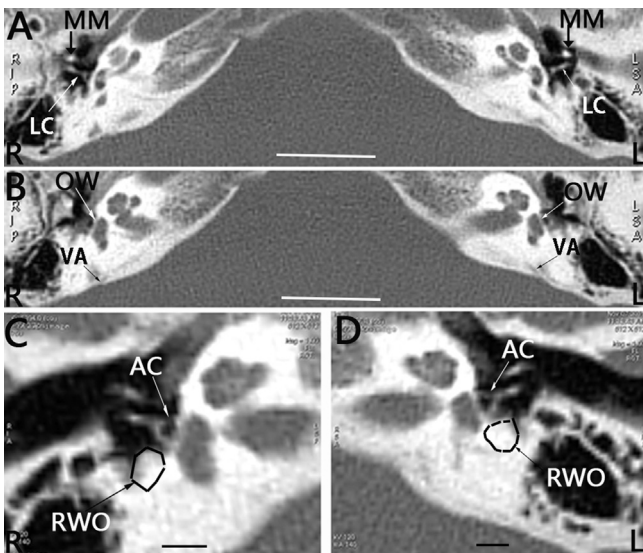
CT image of the inner ear in a patient with bilateral sudden sensorineural hearing loss. The middle ear (A) and inner ear including the vestibular aqueduct (VA) are (B) normally developed. The bright signal in area of round window membrane (black frame) indicates round window membrane ossification (RWO) in both ears (C). AC: anterior crus of the stapes; LC: long crus of the incus; MM: manubrium of malleus; OW: oval window. Scale bars = 10 mm in A and B, and 5 mm in C and D.
